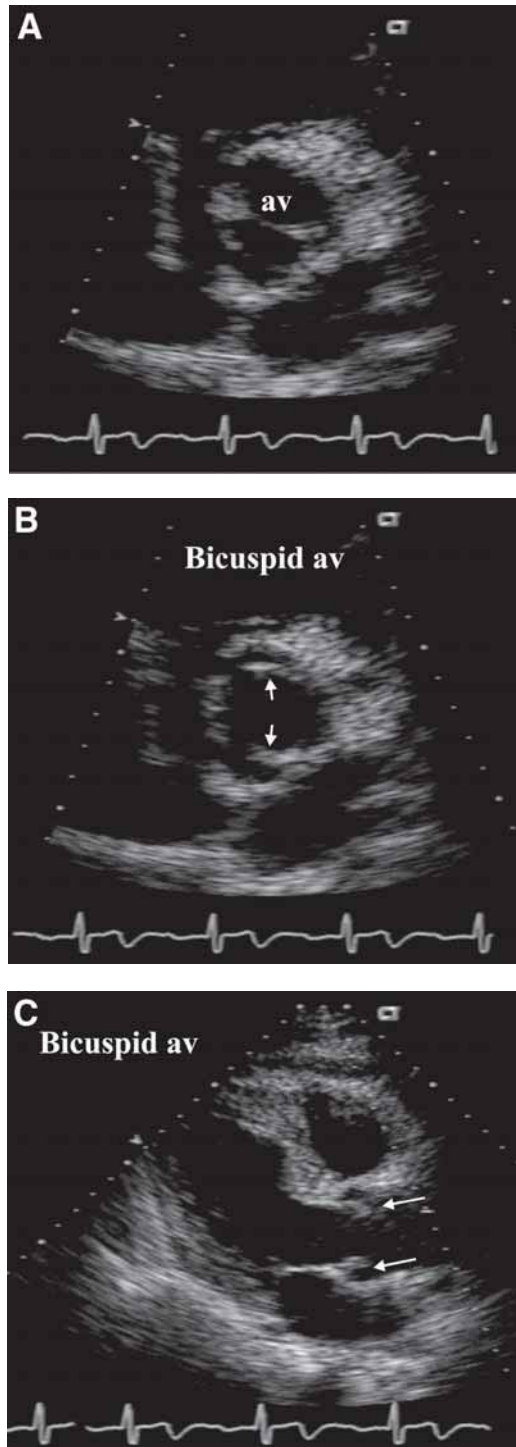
Stop frames from two-dimensional echocardiogram taken from a patient with a bicuspid aortic valve and aortic ejection click. The short axis shows the two cusps (A) in the closed position and (B) in the open position. The aortic valve cusps are seen to be slightly domed in systole (arrows) as observed in the parasternal long axis (C).
